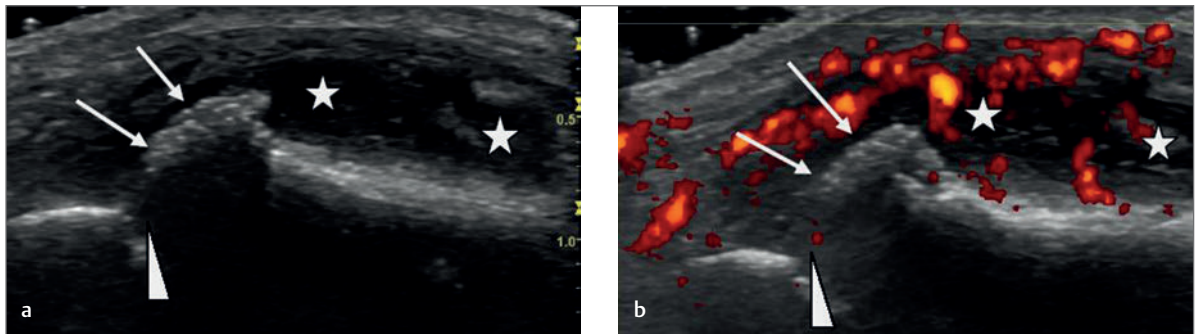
(a) Longitudinal image of the metacarpophalangeal joint of the thumb (*arrowhead*). The head of the metacarpal appears prominent in relation to the phalanx indicative of subluxation (*white arrows*). In addition, there appears to be a significant effusion and synovial thickening (*white stars*). The patient had a chronic and active rheumatoid arthritis. (b) This is the same image as in part (a) except that Power Doppler imaging has been used to demonstrate that the thickened synovium is actively inflamed with a marked synovitis. White arrows, prominent metacarpal; white stars, effused joint with synovial thickening and an active synovitis as demonstrated with Power Doppler imaging.
